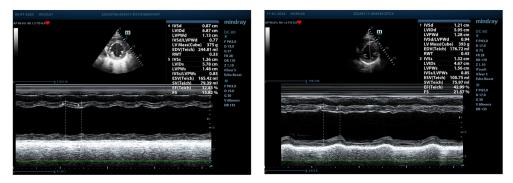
a.5. Measurement of the left ventricle dimensions at first echocardiographyc evaluation (left) (LVEDD = 6.87 cm, LVESD = 5.78 cm, reduced contractility of the inferior wall) and after 6 months (right) (LVEDD = 5.95 cm, LVESD = 4.67 cm) (M-mode, parasternal short axis view, middle section)
